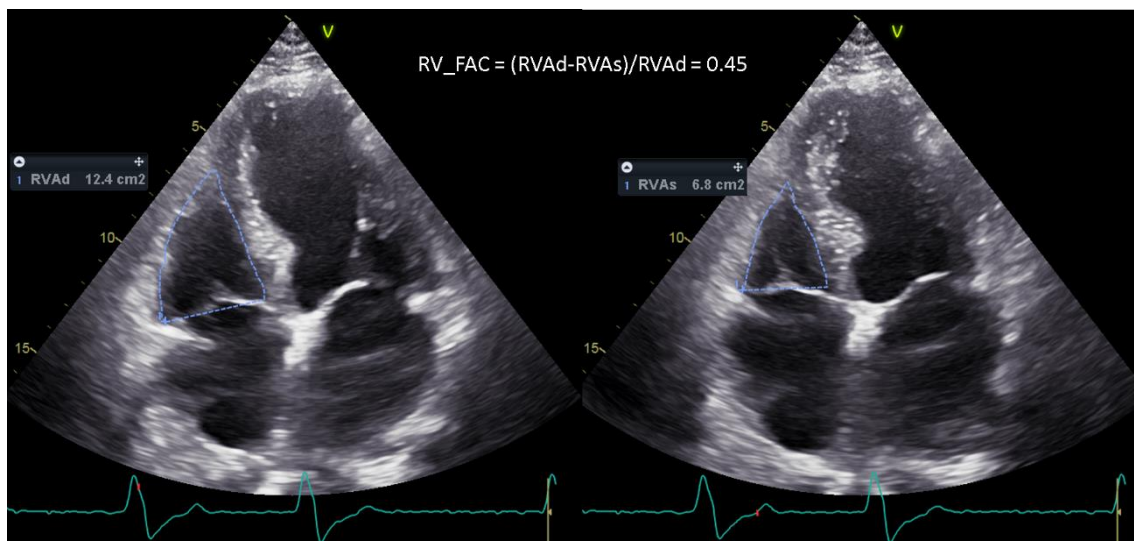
Echocardiographic measurement of fractional area change (FAC). Right ventricular end-diastolic (RVAd) and end-systolic areas (RVAs) are measured from an apical 4-chamber view. FAC is calculated as: $(RVAd - RVAs) / RVAd$.
